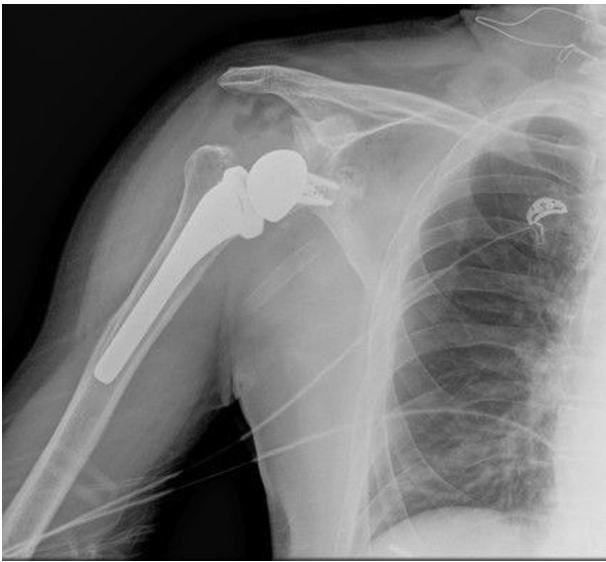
Immediate postoperative anteroposterior radiograph of the right shoulder after reverse total shoulder arthroplasty revision.
